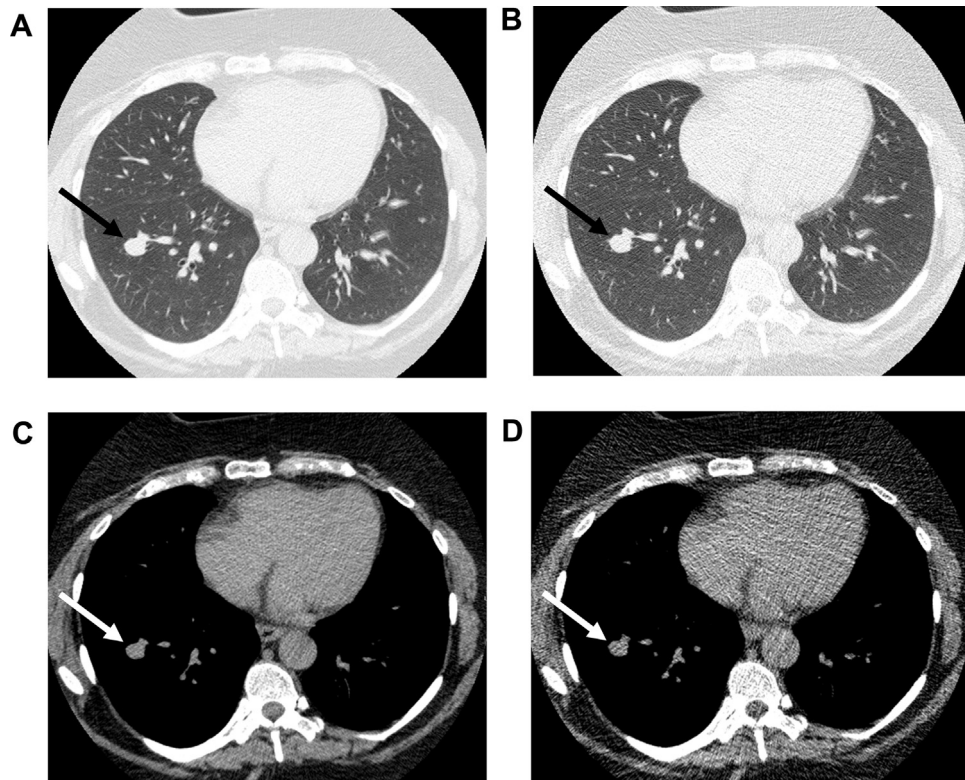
(a and c, standard dose images; b and d, low dose images) 57 year-old female (body weight 120 kg) who underwent chest CT for a follow-up of solitary pulmonary nodule in the right lower lobe. The nodule appears as an oval smoothly margined nodule on both standard dose CT image and low dose CT image (arrow).
